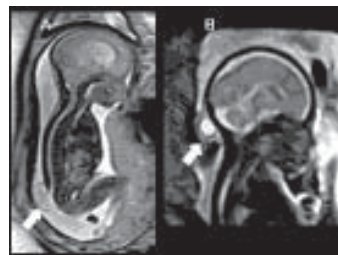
A&B, Meningocele seen on Fetal MRI as a midline defect in lower spine. A thin-walled fluid-filled sac is detected in relation to the defect. The thin wall suggests a non-skin covered back mass. Figure 3 B demonstrates Occipital meningocele with a rounded fluid-filled sac in the occipital region. No contents are seen within it ruling out an encephalocele. The outer wall covering is thick and double layered suggesting a skin covering.
